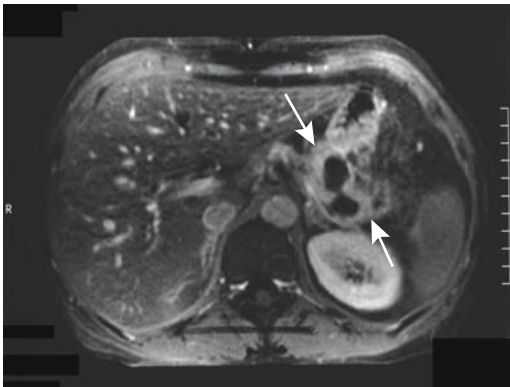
Abscess involving pancreatic tail. Contrast-enhanced magnetic resonance imaging (MRI) identifies a peripheral enhancing rim (arrows) containing nonenhancing components. (Source: From Burgener FA, Meyers SP, Tan RK, Zaunbauer W. *Differential Diagnosis in Magnetic Resonance Imaging*. Stuttgart: Thieme, 2002, with permission.)
